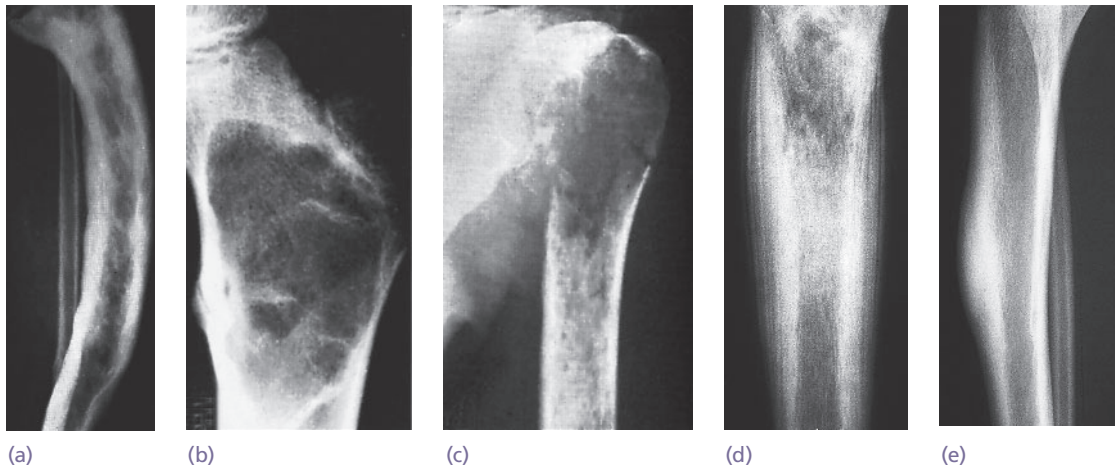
X-rays – important features to look for (a) *General shape and appearance*, in this case the cortices are thickened and the bone is bent (Paget's disease). (b,c) *Interior density*, a vacant area may represent a true cyst (b), or radiolucent material infiltrating the bone, like the metastatic tumour in (c). (d) *Periosteal reaction*, typically seen in healing fractures, bone infection and malignant bone tumours – as in this example of Ewing's sarcoma. Compare this with the smooth periosteal new bone formation shown in (e).
